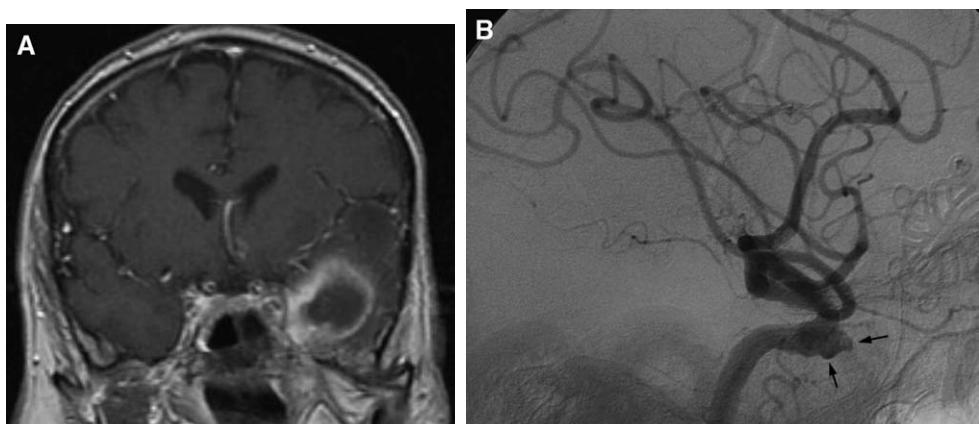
(A) Controlled intraoperative bleeding encountered during removal of a medial temporal lobe abscess, seen on MRI, associated with mucoepidermoid carcinoma. Angiography showed minor intimal irregularity (not shown). (B) Massive oral bleeding occurred 5 months later; revealed a pseudoaneurysm (arrows) which was treated by carotid occlusion.
